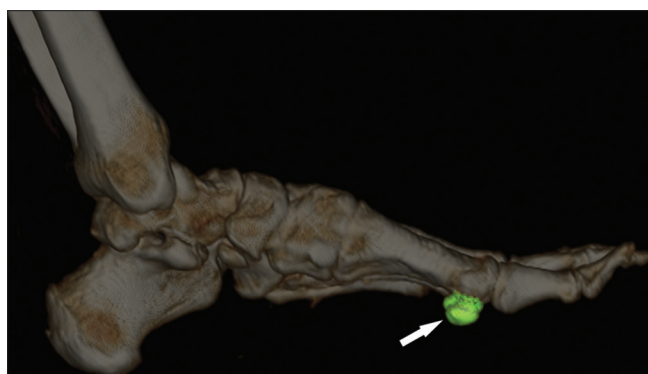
Volume-rendered ^{99m}Tc methylene diphosphonate (MDP) single photon emission tomography-computed tomography (SPECT-CT) images of right foot. The volume of focal uptake of SPECT (arrow) is superimposed on the volume-rendered CT images. Characteristic pattern of uptake in the sesamoid bone is seen
